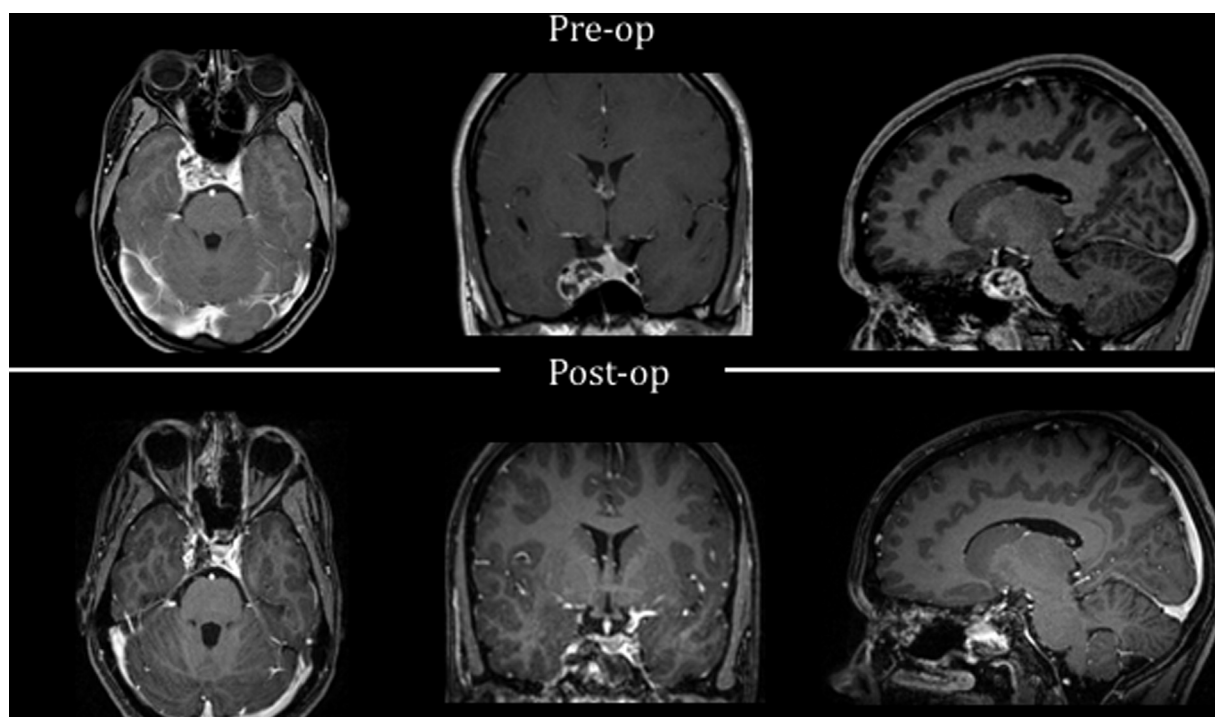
Pre- and postoperative T1-weighted postgadolinium magnetic resonance imaging.
